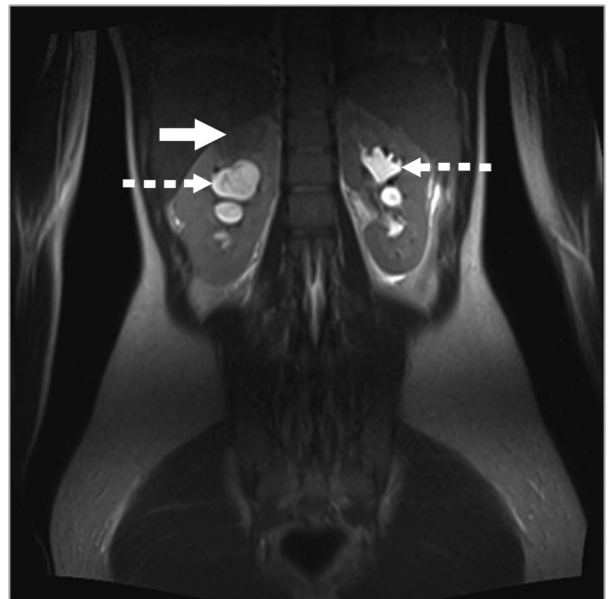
Abdominal magnetic resonance imaging scan revealing substantial obstructive hydronephrosis of the kidneys (*broken arrows*), right kidney greater than left. Signal distortion in the superior portion of the right renal parenchyma suggests acute lobar nephronia (focal infection) and pyelonephritis (*solid arrow*).
